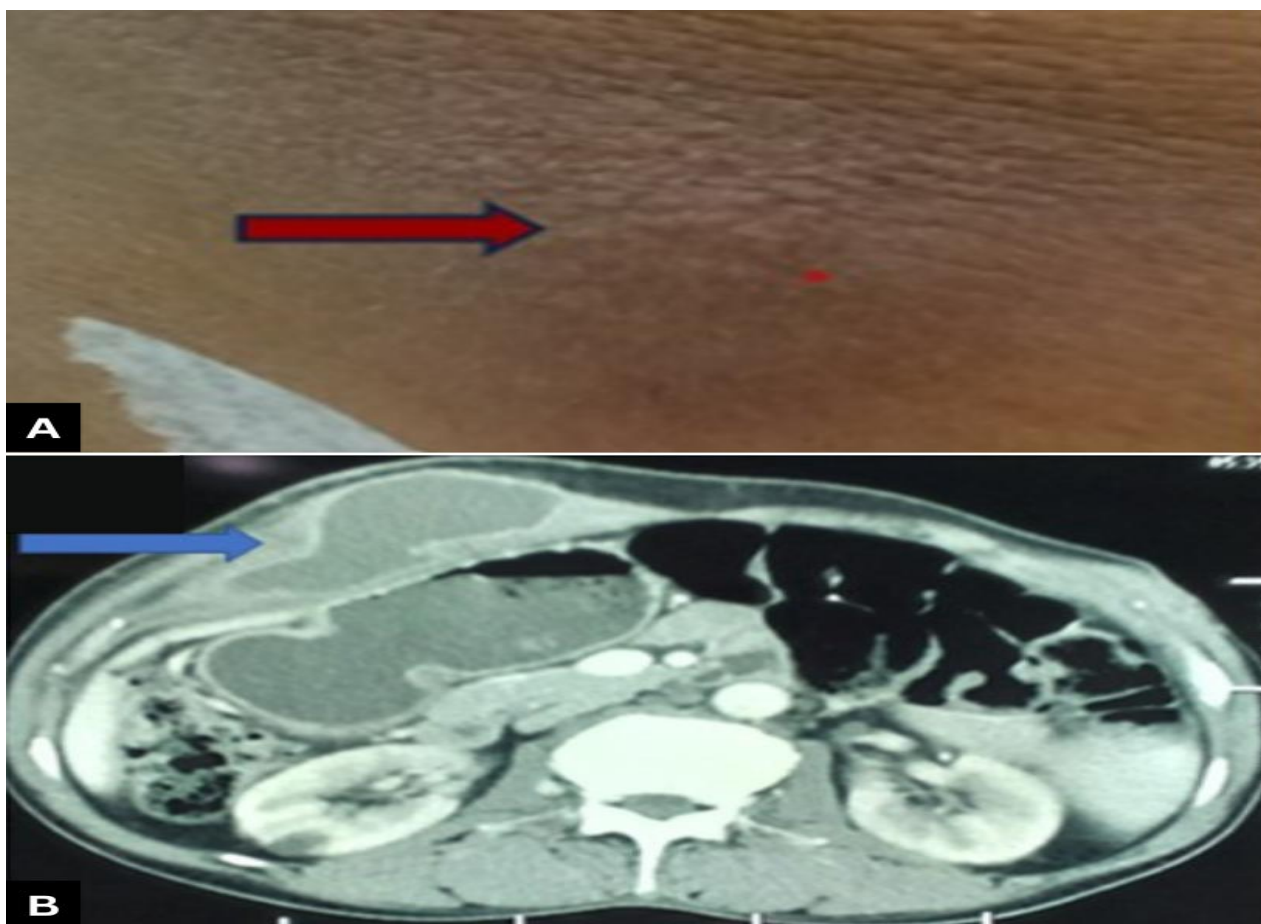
A) Abdominal swelling with sinus tract. B) CT showing subcutaneous collection
